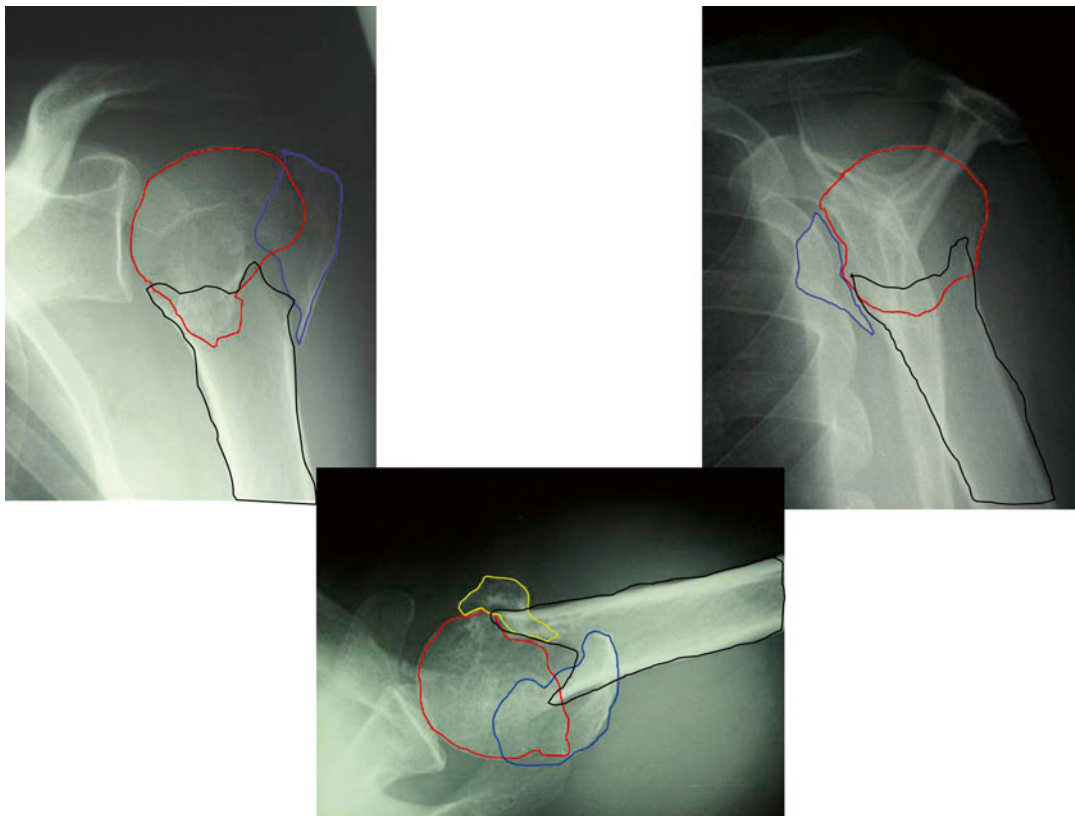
A complete X-ray trauma series for the shoulder. Fragments of fracture. *red head, blue greater tuberosity, yellow lesser tuberosity, black diaphysis*
